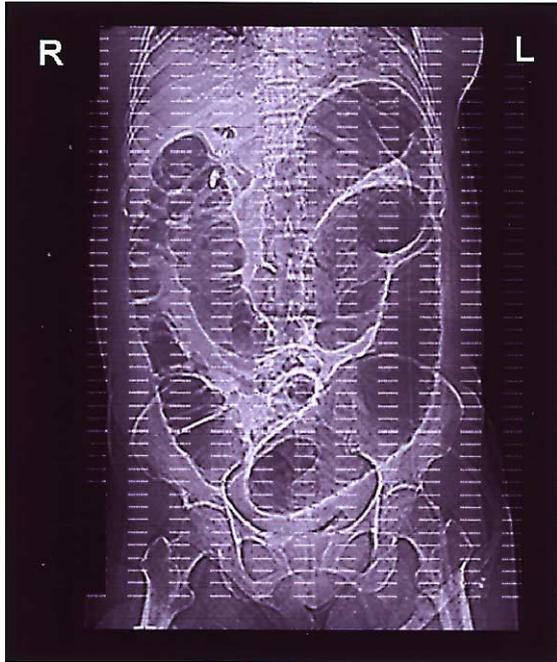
An X-ray CT scout image obtained on day 23 was shown. A dilated length of colon is evident.
